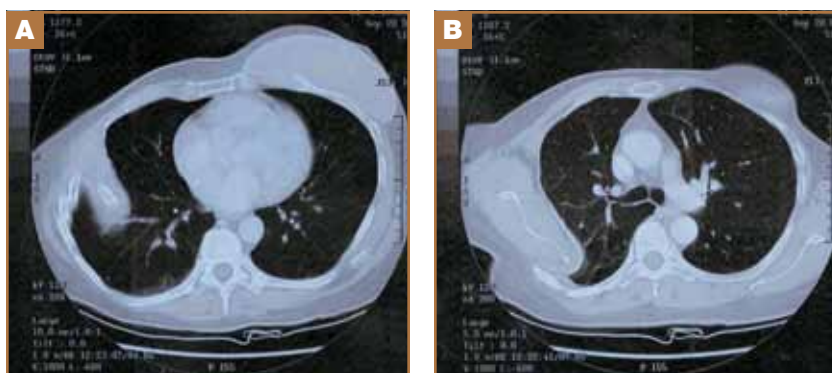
Axial CT scan of the chest shows the inferior angle of the right scapula in an intrathoracic location (A). A more proximal cut shows the scapular body in an intrathoracic location (B).
